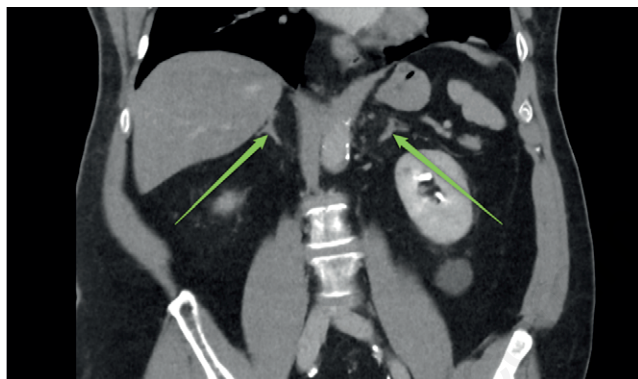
First abdominal computed tomography scan with contrast (coronal view) showing normal adrenal glands (green arrows).
